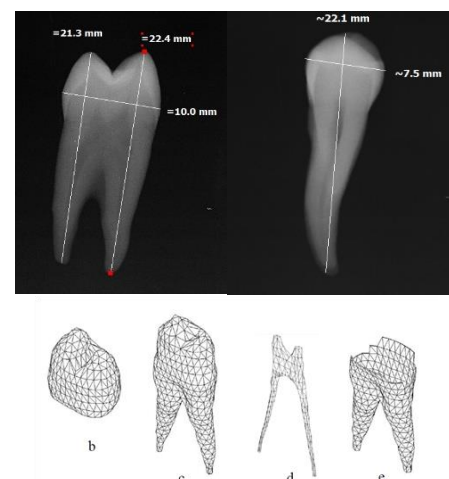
a. Parallel periapical radiographs from buccal and mesial aspects of a maxillary two-rooted premolar. b, c, d, and e. volumetric geometry of the enamel, dentin, and pulp
